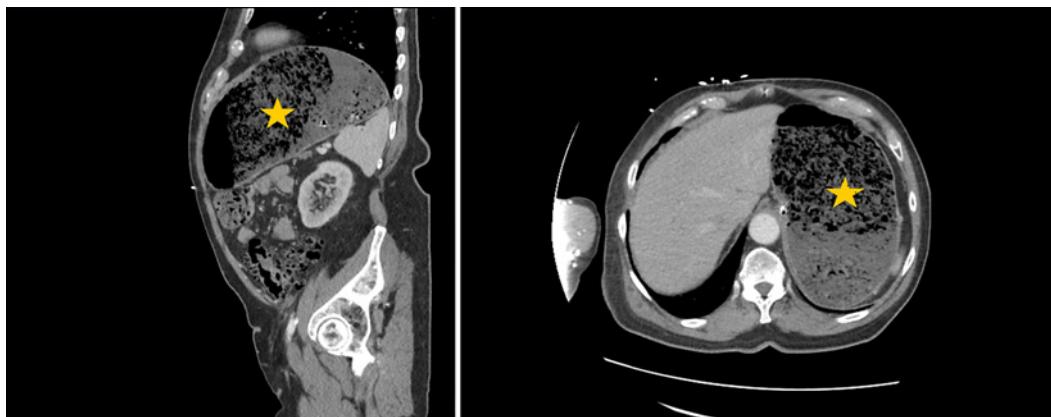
A contrast-enhanced CT scan of the abdomen and pelvis (sagittal and axial planes) showing significant distension of the stomach containing food debris.
